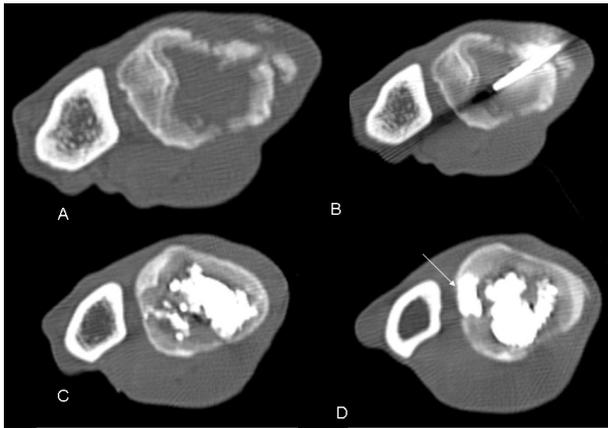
The CT shows an expansile lytic bone lesion of the ulna (A). Different phases of the CT-guided cementoplasty: bone needle is visible within the bone (B) and two CT slices at different levels of the cyst (C, D). Good filling of the cavity is visible. The filling of an area of lytic cortex is also visible (arrow)
